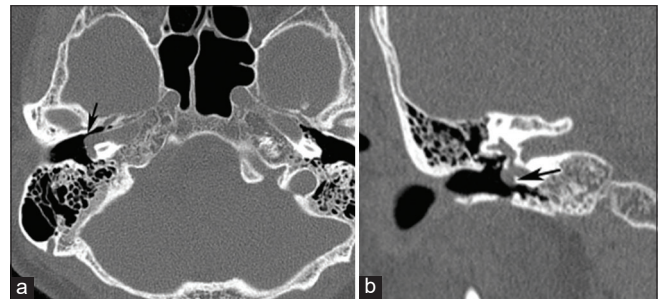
A 29-year-old man with aberrant right internal carotid artery (ICA). (a) Axial high-resolution computed tomography image and (b) coronal multiplanar reformation (b) reveals abnormally aberrant right ICA (arrows), coursing through the middle ear cavity and overlying the cochlear promontory.
